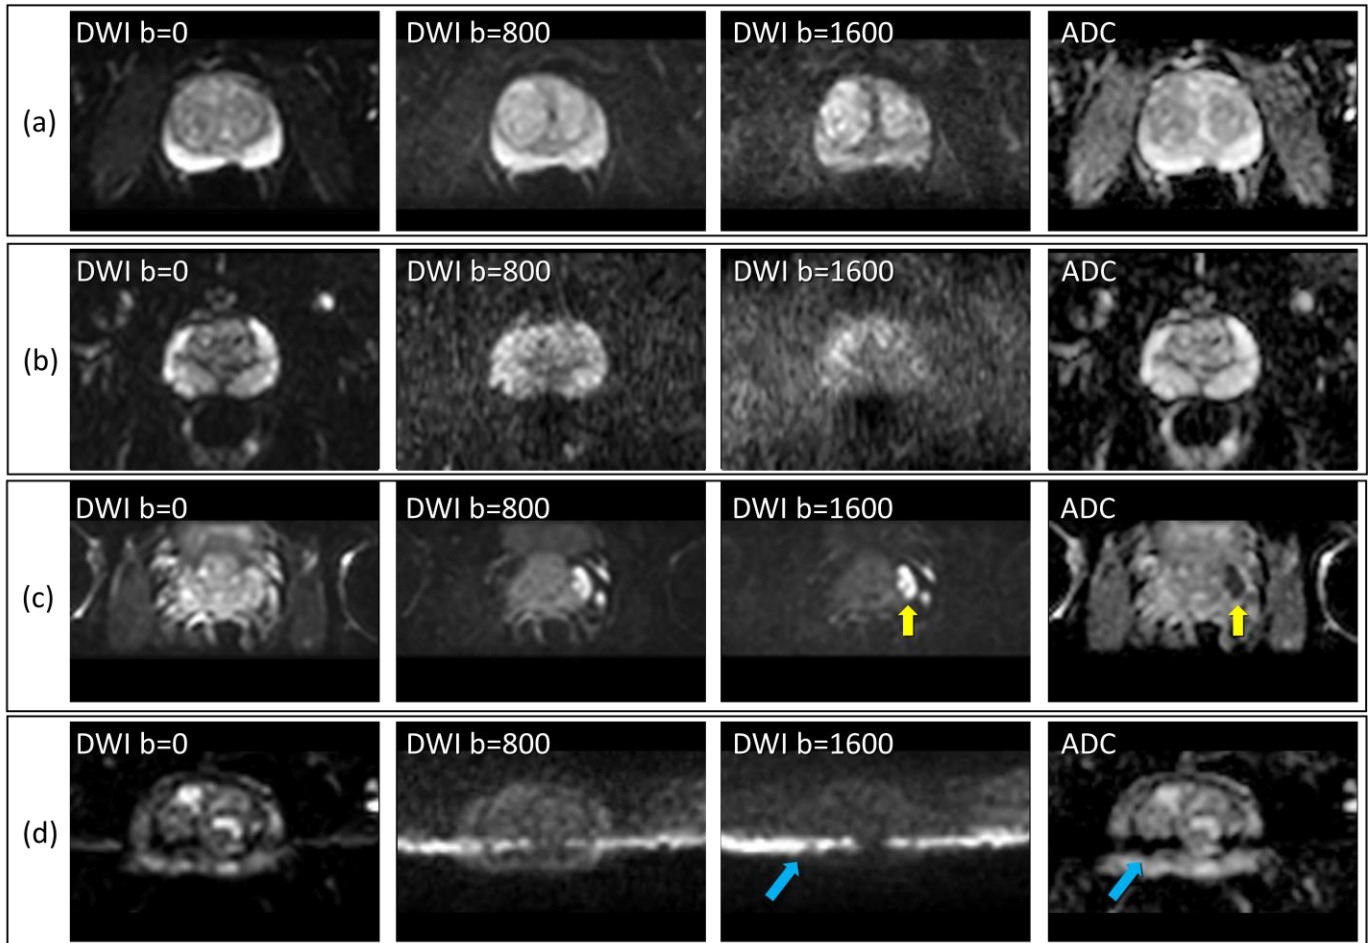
Visual assessment of SNR in prostate DWI; (a) an example of good SNR at all  $b$ -values; (b) poor SNR at  $b=1600$   $s/mm^2$  where anatomical features of gland are barely above noise floor thus are prone to biased ADC values; (c) modest SNR in normal gland at  $b=1600$   $s/mm^2$  although good SNR in lesion due to low ADC (yellow arrows); (d) poor SNR at  $b=1600$   $s/mm^2$  plus a ghost artifact (blue arrows) leads to bias and artifactual ADC.
